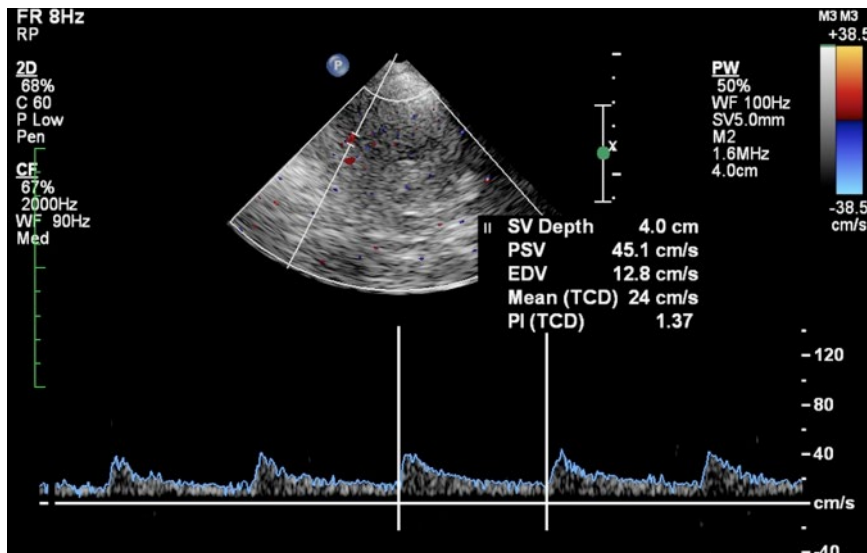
In this image of right middle cerebral artery Doppler flow (waveform at the bottom), the mean flow velocity (MFV) is low (24 cm s^{-1}) and there is an increased pulsatility index (PI) of 1.37. These findings are suggestive of a more distal intracranial arterial stenosis. This image would have been improved by adjusting the Doppler Velocity scale for improved resolution of the waveform (maximum velocity 50 cm/s).
